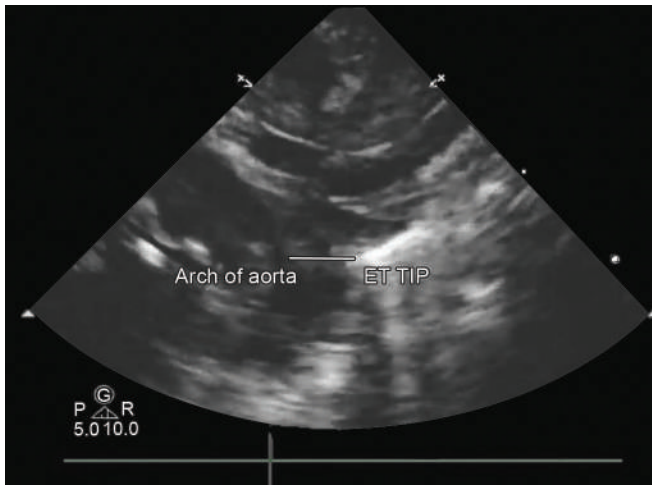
Sonography shows a hyperlucent ETT in the trachea. A distance of 5–10 mm (marked) between the tip of the ETT and the aortic arch is consistent with optimal placement of the tube
